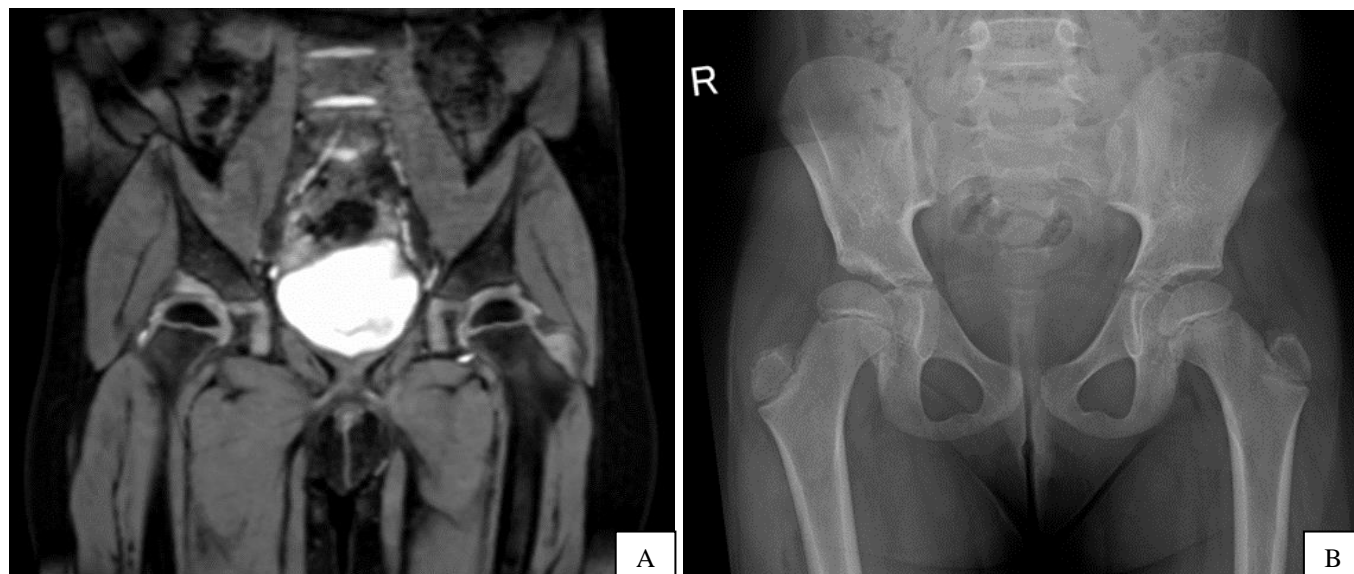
A - Case one, MRI aspect of the hips, at the age of 4 years, the right hip is displastic but the cartilaginous part of the acetabulum covers perfectly the femoral head. B - Case one, X-ray image of the pelvis on A-P view, at the age of 6 years, the right hip is slightly dysplastic but the Wiberg angle is positive, a surgical procedure to improve the right hip coverage may be required in the future.
